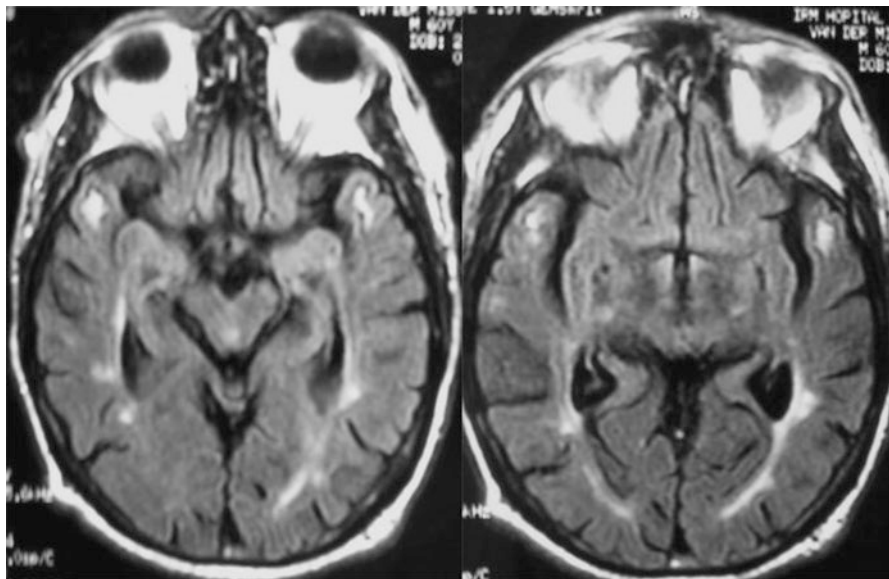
T2-weighted MRI (FLAIR images) showing widespread and symmetrical hyperintensities in the white matter and small deep infarcts (hypointensities) located in the thalamus and within the centrum semiovale. Note the involvement of the external capsules observed in two-thirds of CADASIL patients
